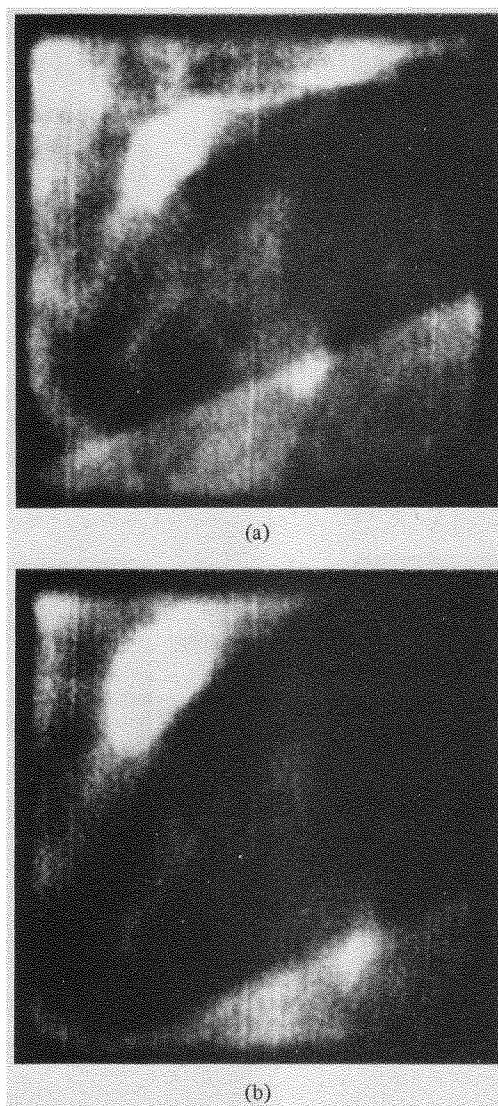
Two digitized, windowed, and reconstructed radiographs of the same object. Radiological magnification: (a) 1.5 \times (b) 2 \times .
